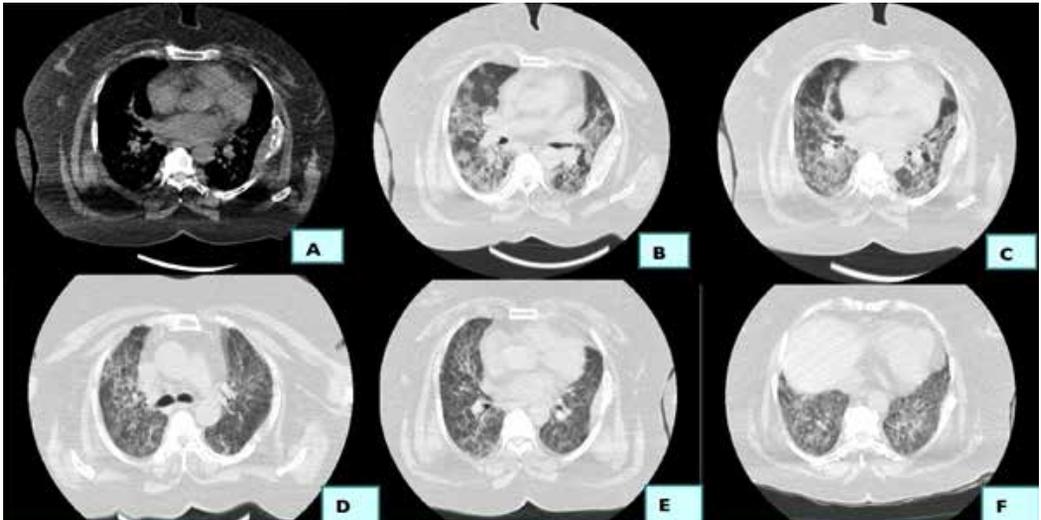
Lung CT of a patient with coronavirus disease 2019
